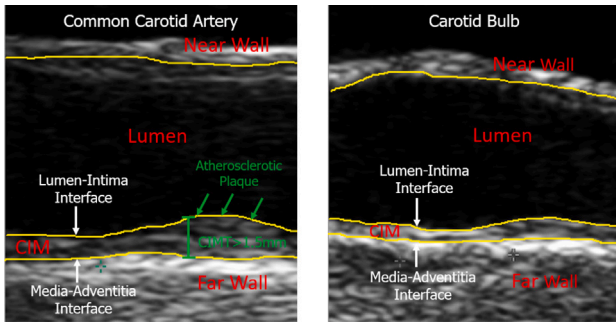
Ultrasound CA images from two territories: common CA (left) and bulb (right). The different parts of the CA are delimited with lines: Near wall, Far wall, Lumen, Bulb, Carotid Intima-Media (CIM) region. In both cases, the CIMT is estimated in the CIM region (between Lumen-Intima Interface and Media-Adventitia Interface). Atherosclerotic plaque is also shown (portion of the CIM with a CIMT greater than 1.5 mm [1]).
